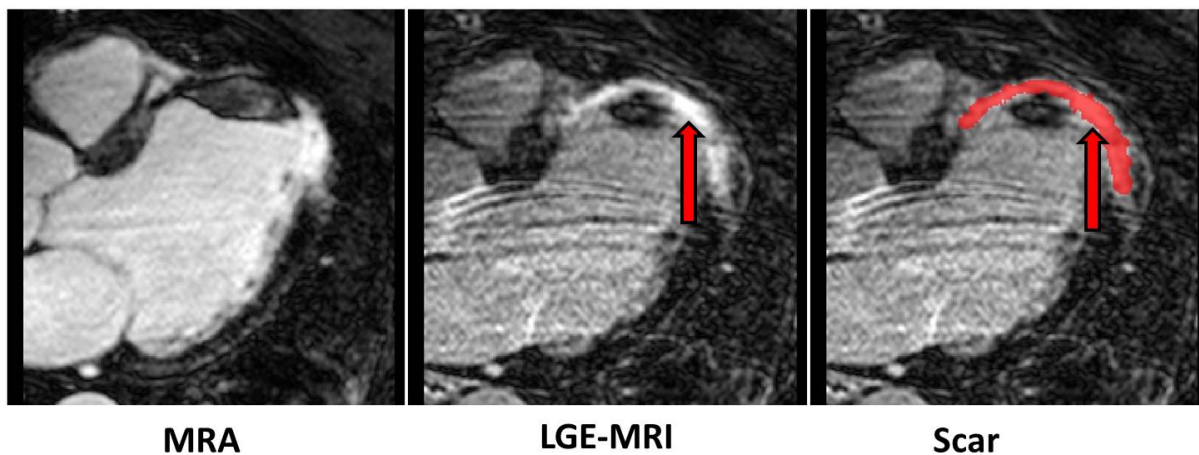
The MRA and LGE-MR images of the same patient with the myocardial scar. The MRA image (on the left) visualizes the heart anatomy well while the LGE-MR image (middle and the right) highlights the scar structure. The scar is manually segmented on the LGE-MR image in red (on the right).
